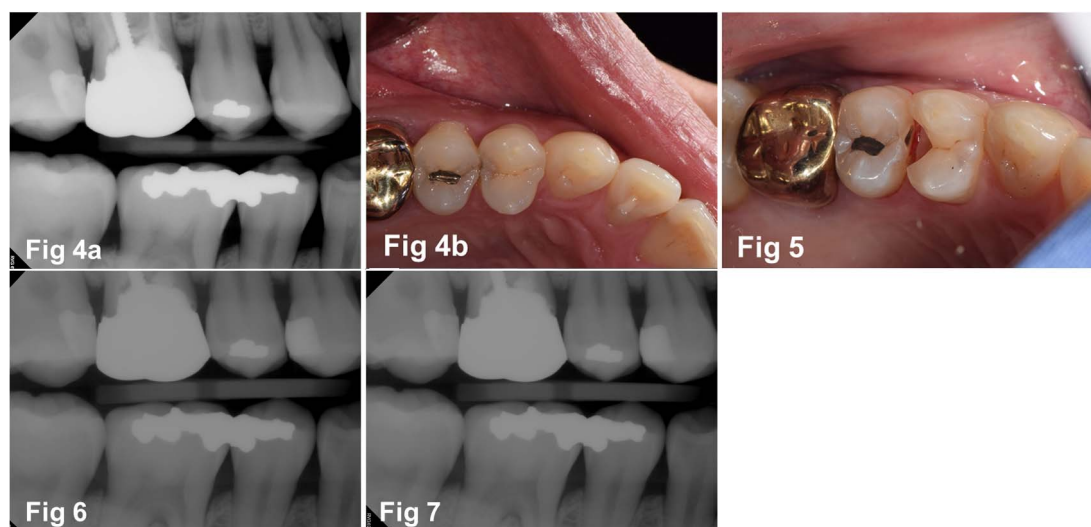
(a) Six-year follow-up on radiograph. (b) Six-year follow-up on clinical photo. #4 mesial proximal caries had not progressed, but the #5 distal proximal caries had progressed to the dentin area, and a distinct color change was observed.
